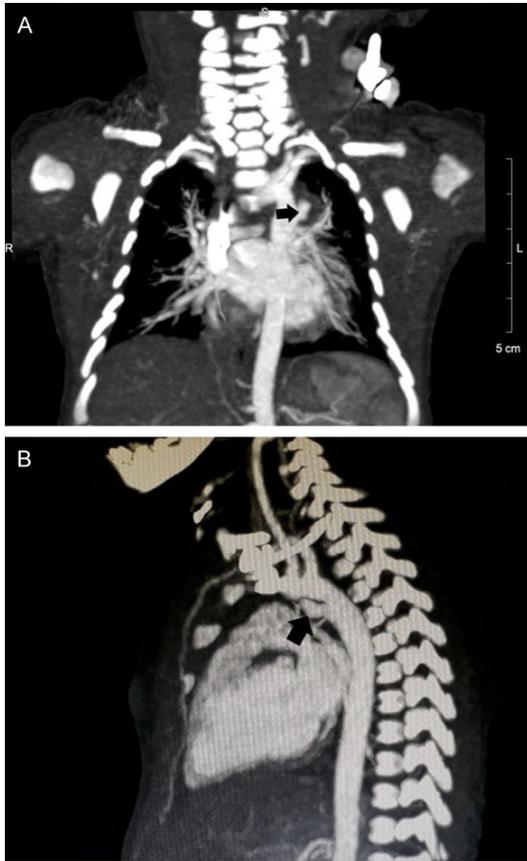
CT of the heart and vessels showed a ductus arteriosus aneurysm, 0.7 cm in diameter (arrow) (A: AP view, B: Lateral view).
